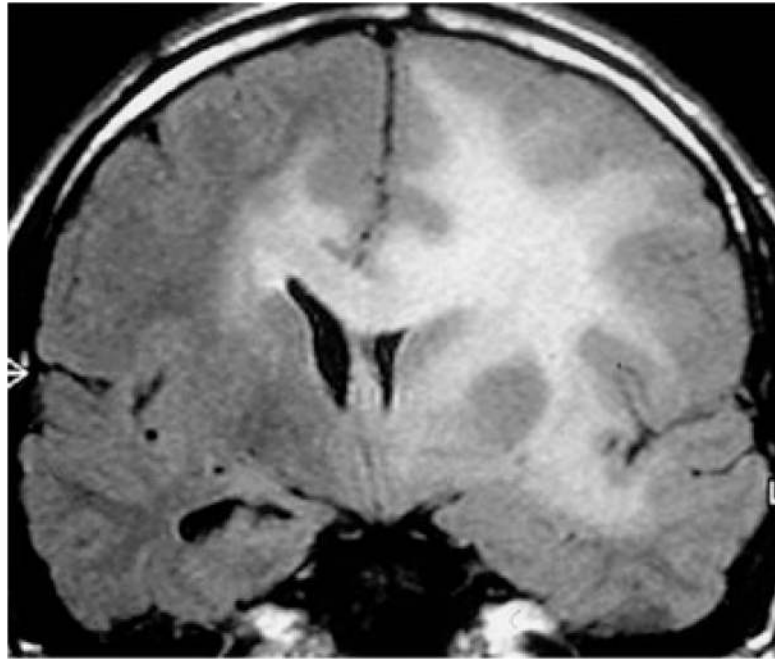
Coronal T1-weighted image in a patient with gliomatosis cerebri. Note the spread of tumor along white matter planes.
